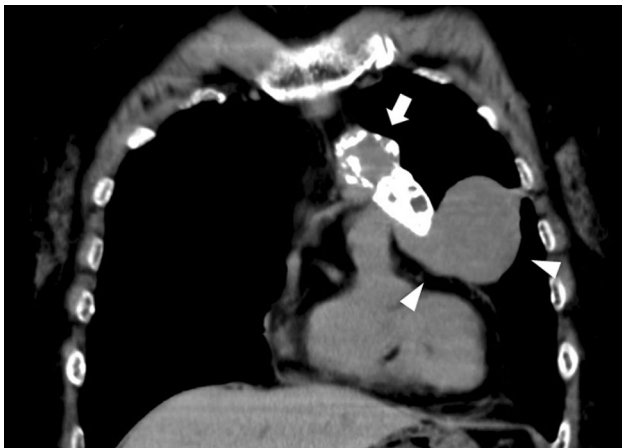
Chest CT revealed a calcified nodule at the anterior mediastinum (*white arrow*) and a caudal mass adhered to the left lung and pericardium (*white arrowheads*)
